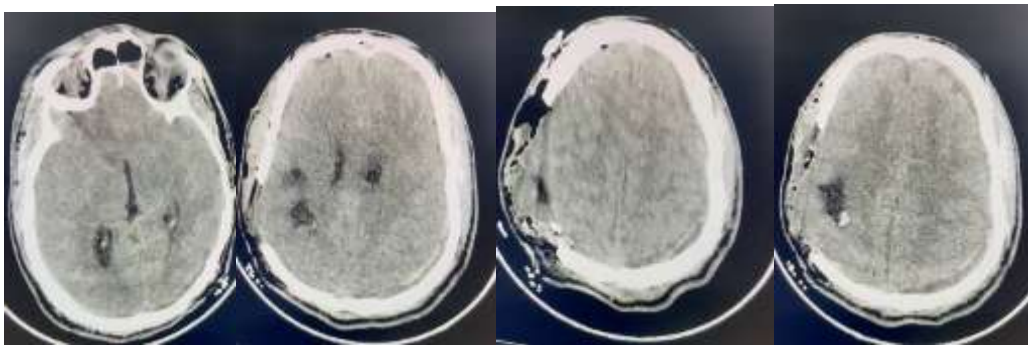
Postoperative day-1 brain CT showing regression of the right subdural empyema, with new intraparenchymal collection and increased contralateral parietal hemorrhagic collection.
